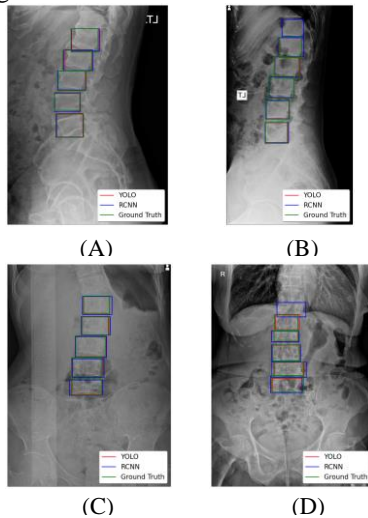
Comparison of YOLO and RCNN Localization Performance on Lateral and AP X-ray Views with Associated Uncertainty Scores - (A) and (B): Lateral views with uncertainty scores of 5 and 4, respectively. (C) and (D): Anteroposterior views with uncertainty scores of 5 and 1, respectively
